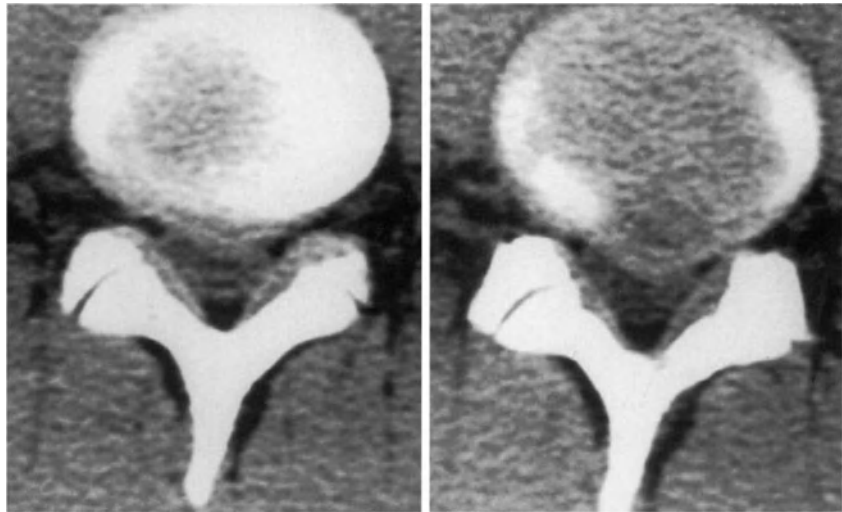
Axial CT images showing a contained herniation at L4-L5 level. The posterior border of the disc shows a focal paramedian convexity on the left and produces an indentation on the corresponding portion of the thecal sac.
